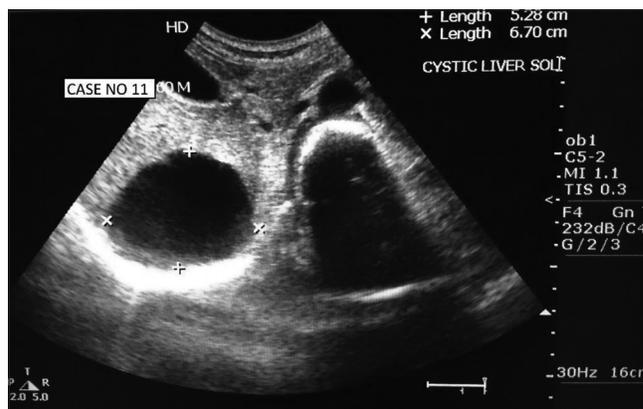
Ultrasonography: Simple hepatic cyst in the right lobe
